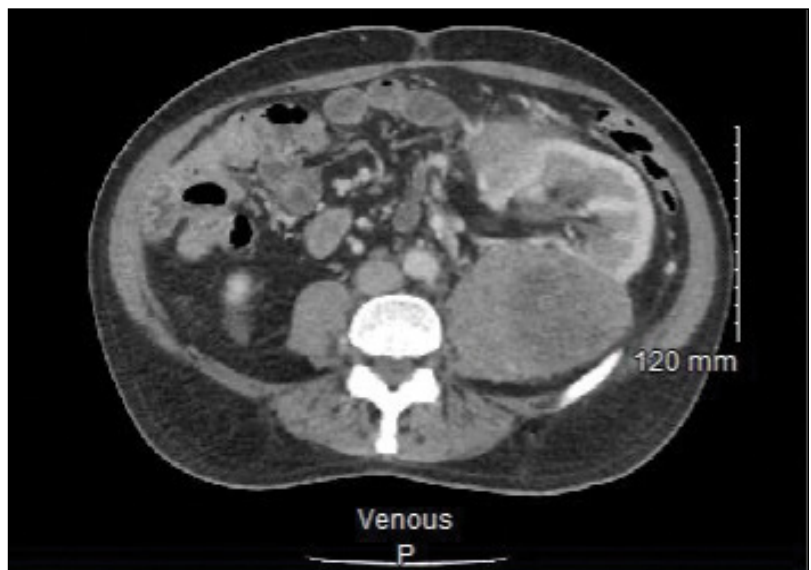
CT abdomen with contrast. Left kidney with anterior displacement due to mass along with other local structures.
